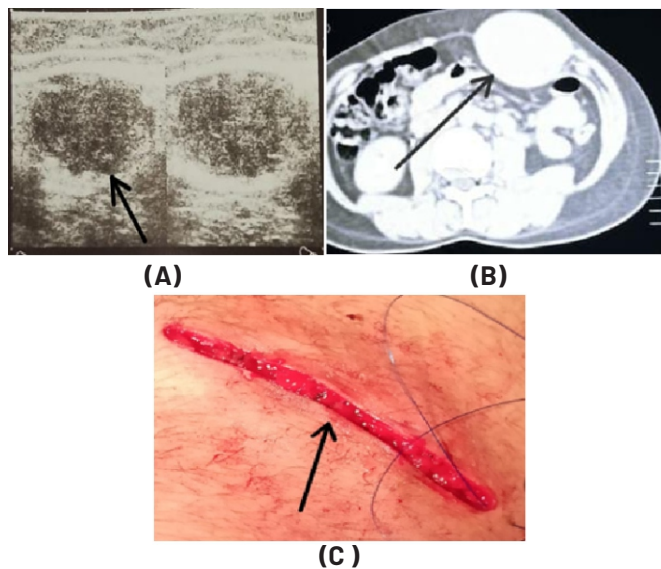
(A) Ultrasound of lesion (B) CT SCAN of Lesion (C) Operative site
